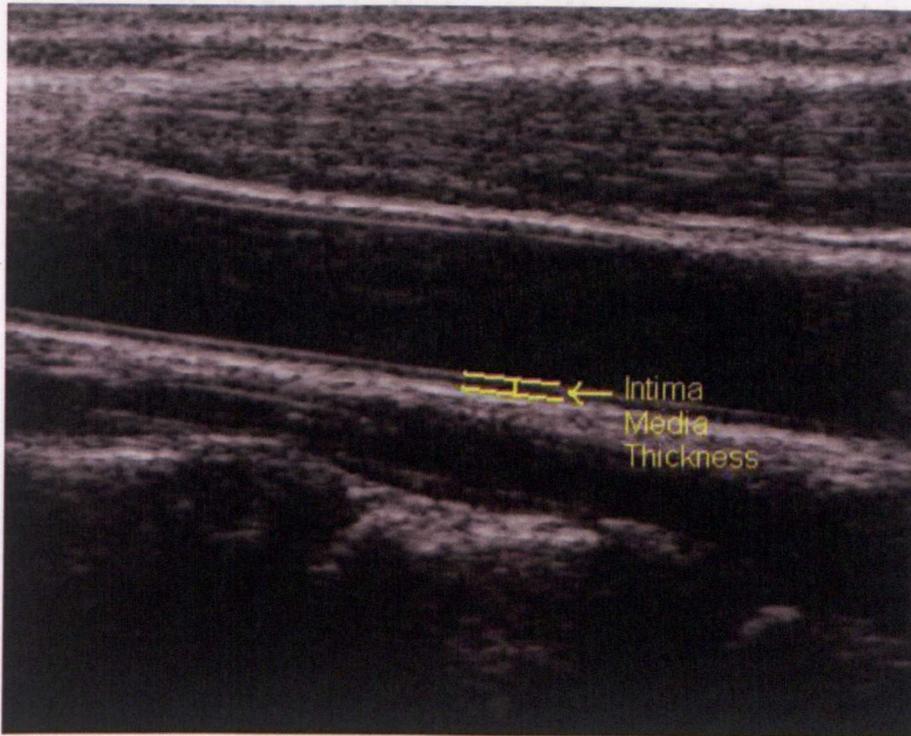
B Mode ultrasound scan indicating Intima Media Thickness. Author's own scan: Image taken from one of participants in study 2.
